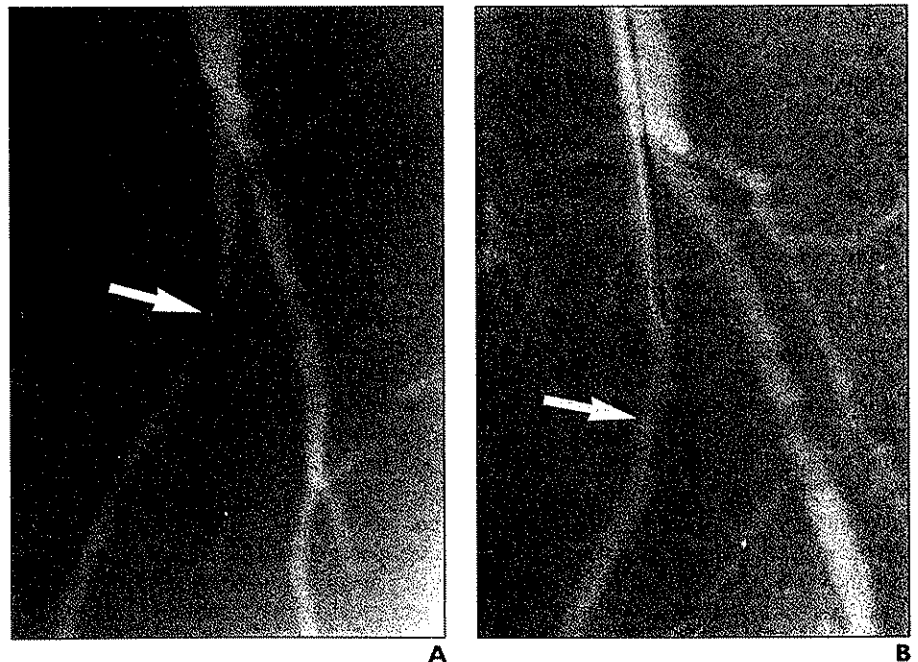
66-year-old man who had previously undergone renal transplantation had surveillance Doppler sonographic examination (not shown) showing significant stenosis in proximal aspect of left common femoral to posterior tibial artery vein bypass graft. He was asymptomatic, and serum creatinine level was 1.9 mg/dl. A, Arteriogram obtained with carbon dioxide (CO₂) as contrast agent shows short 70–80% stenosis (arrow) in vein graft corresponding to abnormality detected by sonography. B, Arteriogram using CO₂ as contrast agent obtained after angioplasty shows good result (arrow). No transluminal pressure gradient was present. CO₂ was used for all localization and imaging.
